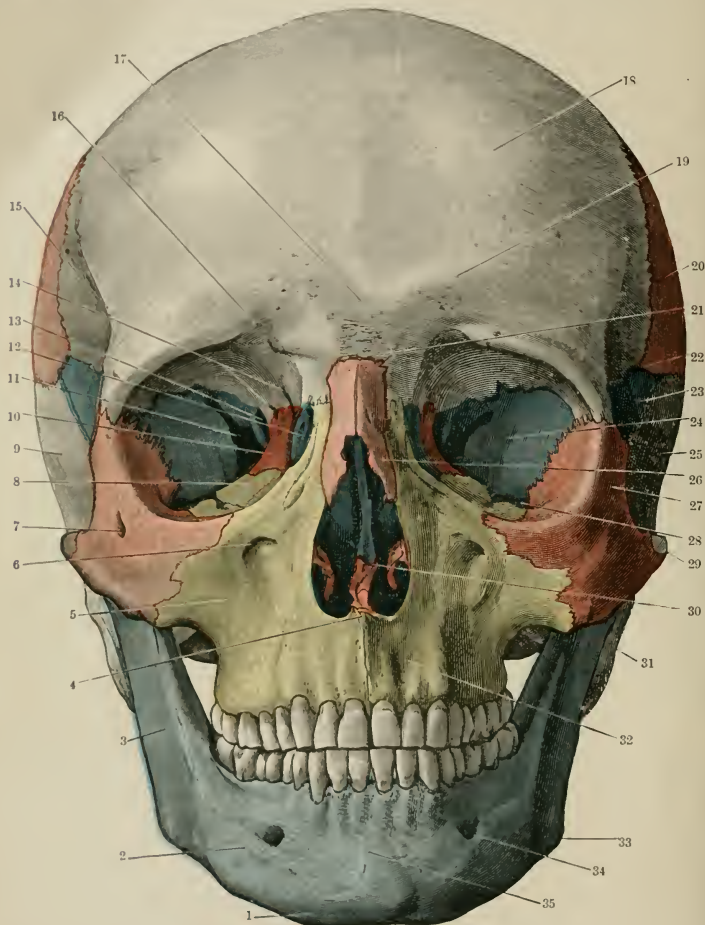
FRONTAL ASPECT OF SKULL.
